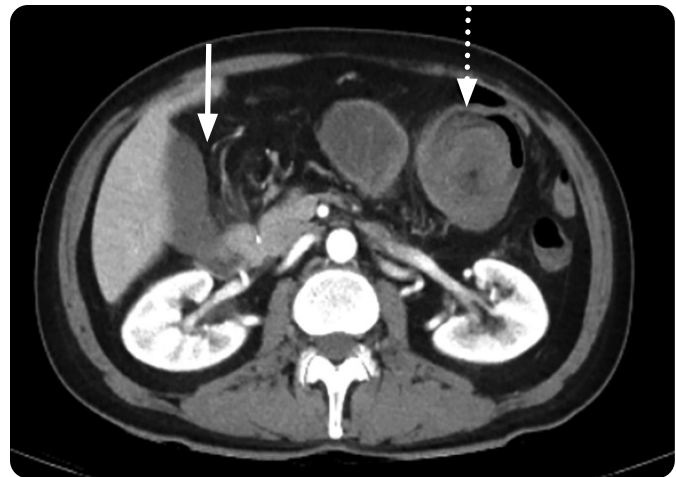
Abdominal axial CT in portal phase. Retraction and swirling of the upper mesenteric vessels (arrow). Target image for intussusception (discontinuous arrow).
